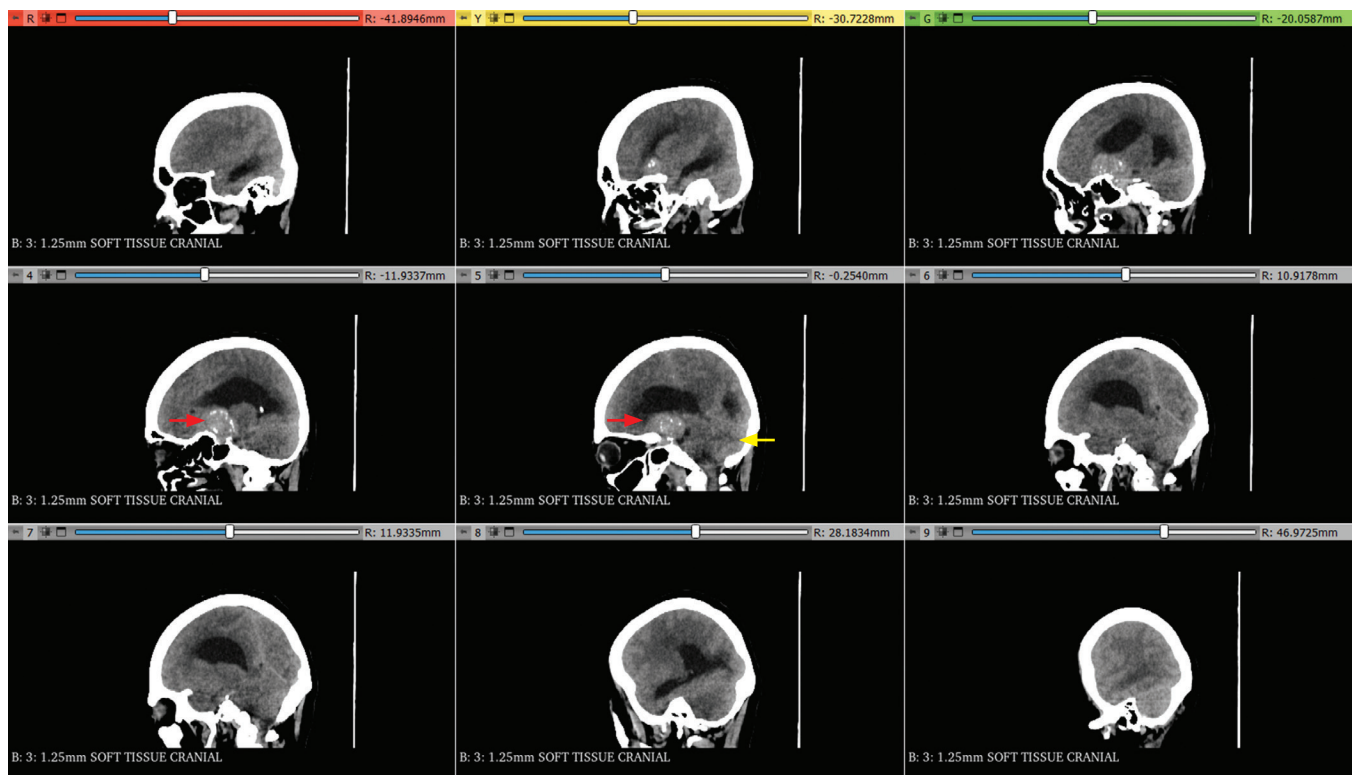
Sagittal view cranial CT scan with contrast. Note the 3.1 x 4.6 x 5 cm mass marked by red arrows in the sellar-suprasellar region. The mass is intimately related to the caudate nucleus and thalamus. Yellow arrow marks the midbrain being pushed inferiorly and posteriorly. No normal pituitary gland can be visualized. Diffuse cerebro-cerebellar edema can be observed.
